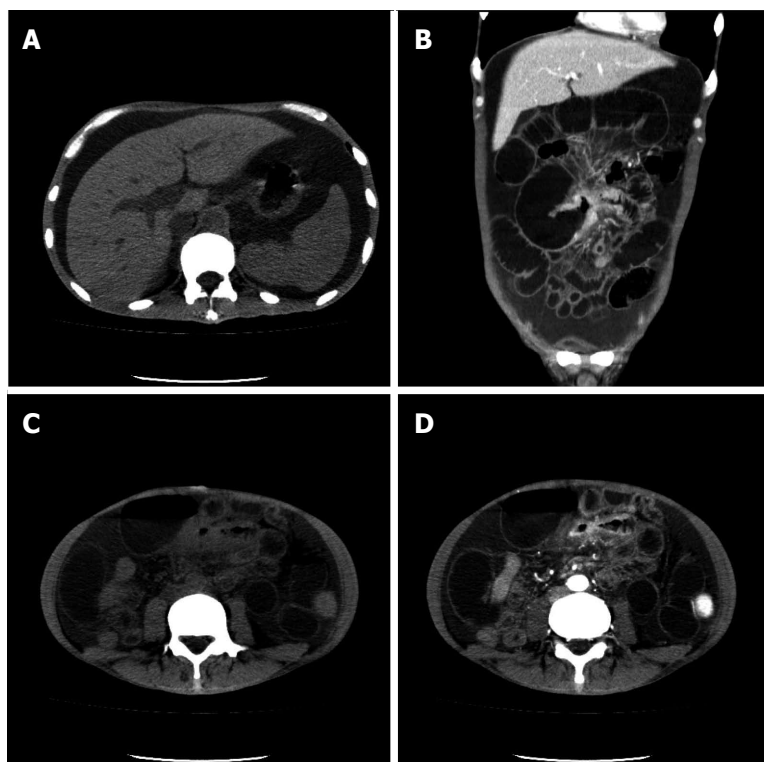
Computerized tomography images indicated hepatosplenomegaly and ascites (A) and the presence of thickened intestinal wall with obvious enhancement in the arterial phase and dilated small bowel (B-D). A: Plain computerized tomography (CT) scan; B: Coronal CT scan; C: Plain CT scan; D: The arterial phase.
